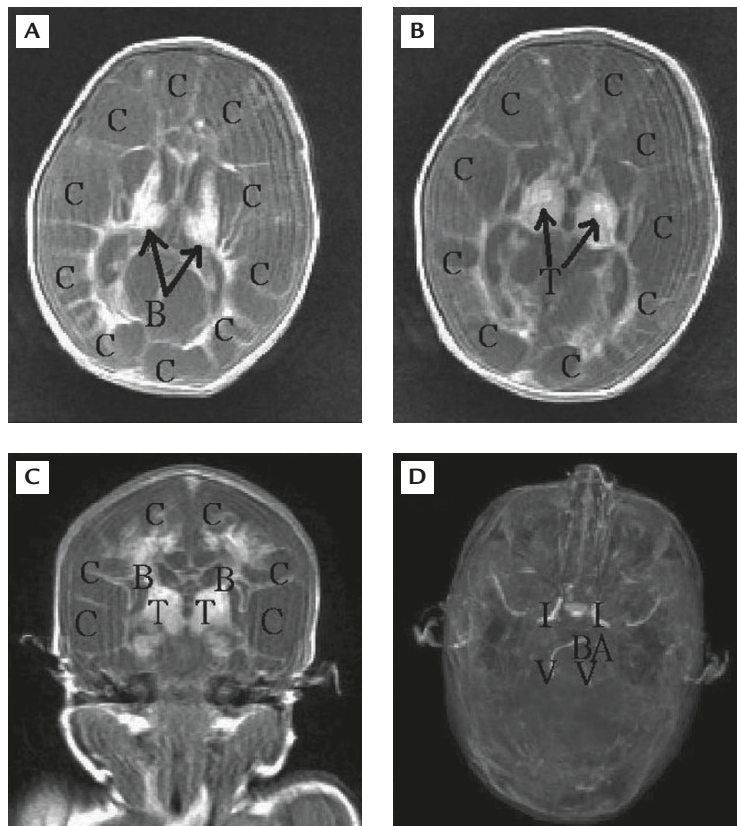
Magnetic resonance imaging of the brain of twin B at 10 days old. (A, B) Transverse and (C) coronal T1-weighted sections. Diffuse multiple cystic formations over the cortex and membranous structure in the bilateral cerebral hemispheres with little cerebral parenchyma. (D) Magnetic resonance angiography reveals that the bilateral internal carotid arteries and vertebrobasilar arteries are patent, but the bilateral middle cerebral arteries, anterior cerebral arteries and posterior cerebral arteries are poorly visualized. B=basal ganglia; C=cystic formations; T=thalamus; BA=basilar artery; I=internal carotid arteries; V=vertebral arteries.
